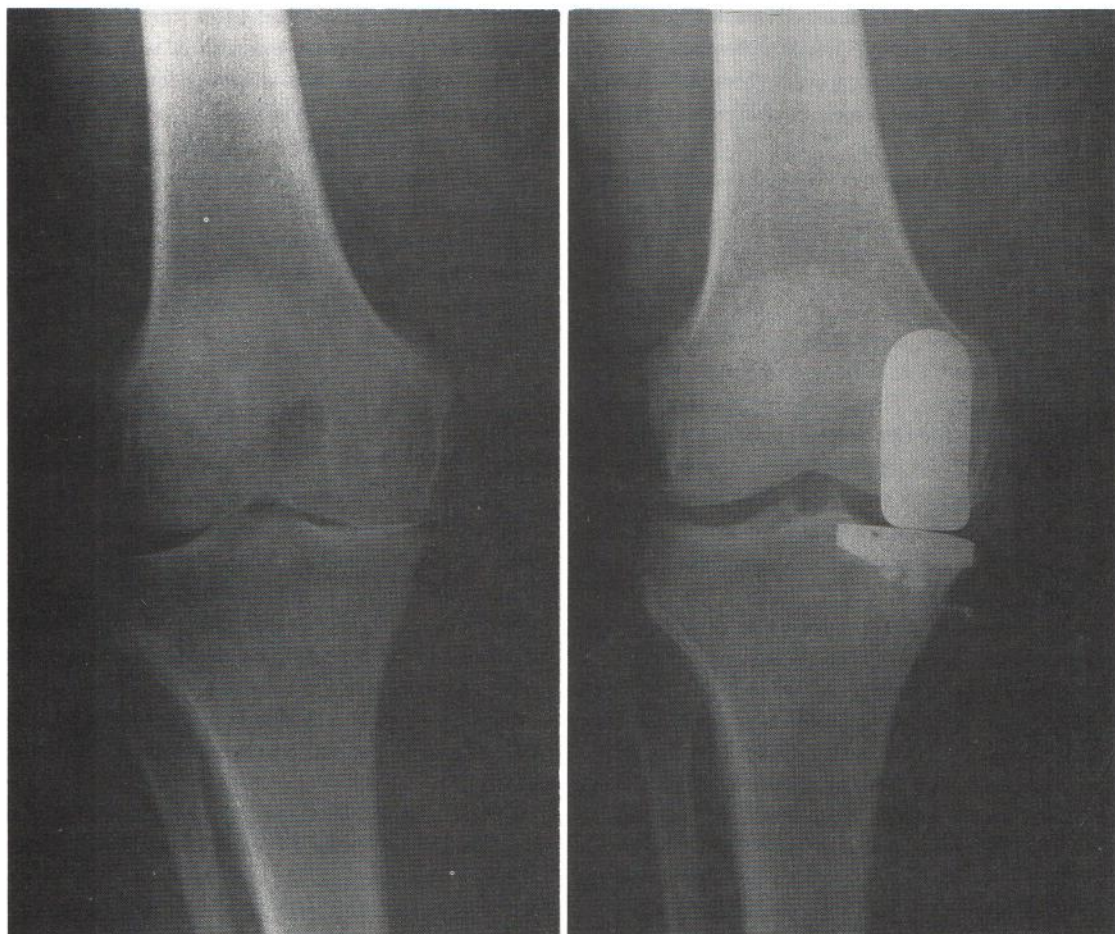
Radiographs of the knee joint with moderate medial osteoarthritis of the knee before and after replacement with a cemented Brigham unicompartmental endoprosthesis.
